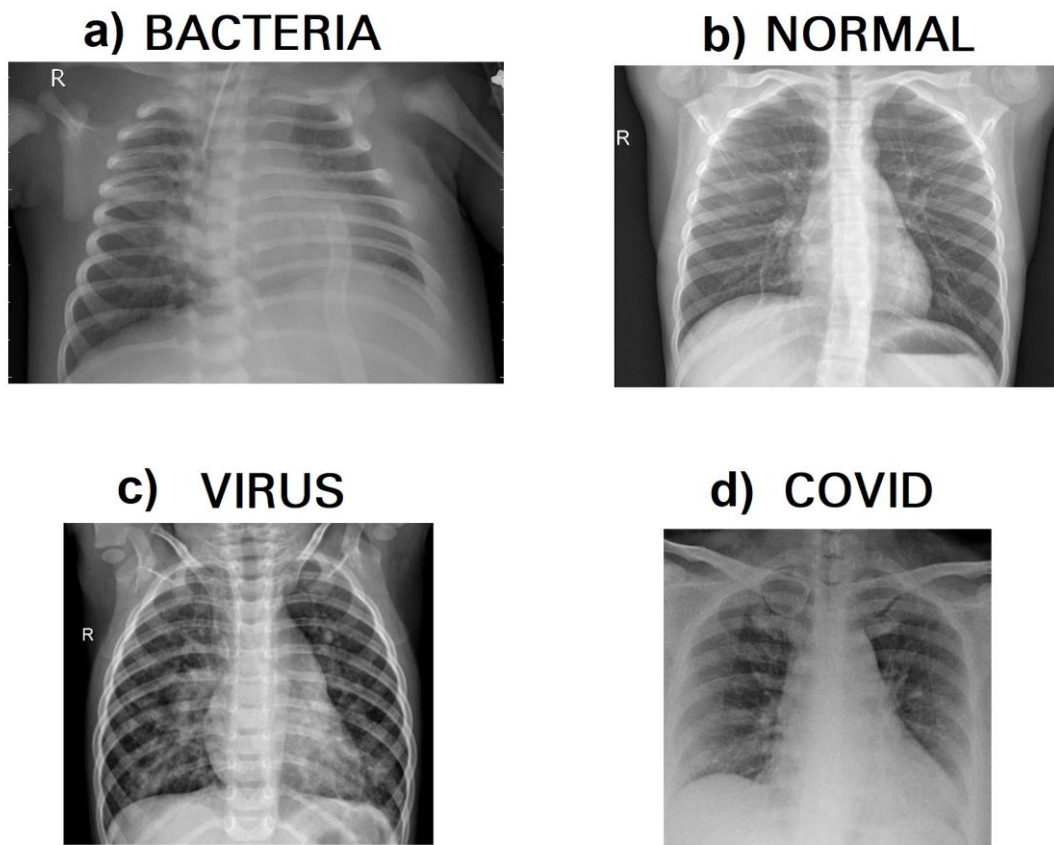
Some Chest X-ray images
